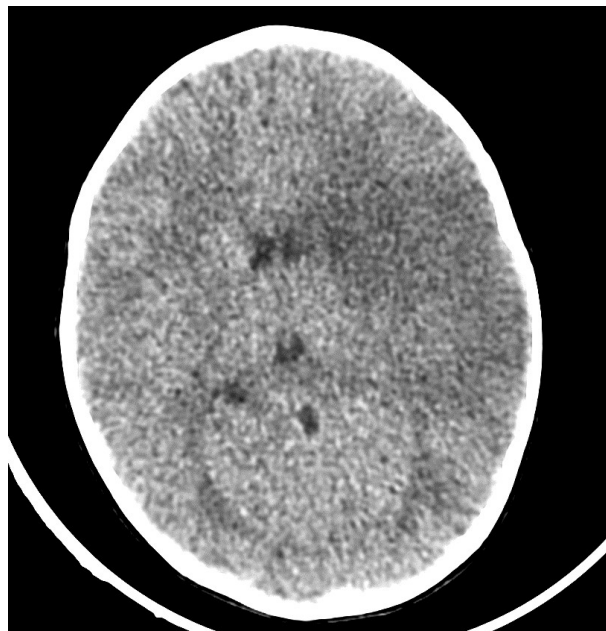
Axial CT scan without contrast injection showing cortico-hypodense subcortical and central nuclei opposite the homolateral sylvian artery spontaneously hyperdense in favor of a recent ischemic attack of the left sylvian.
